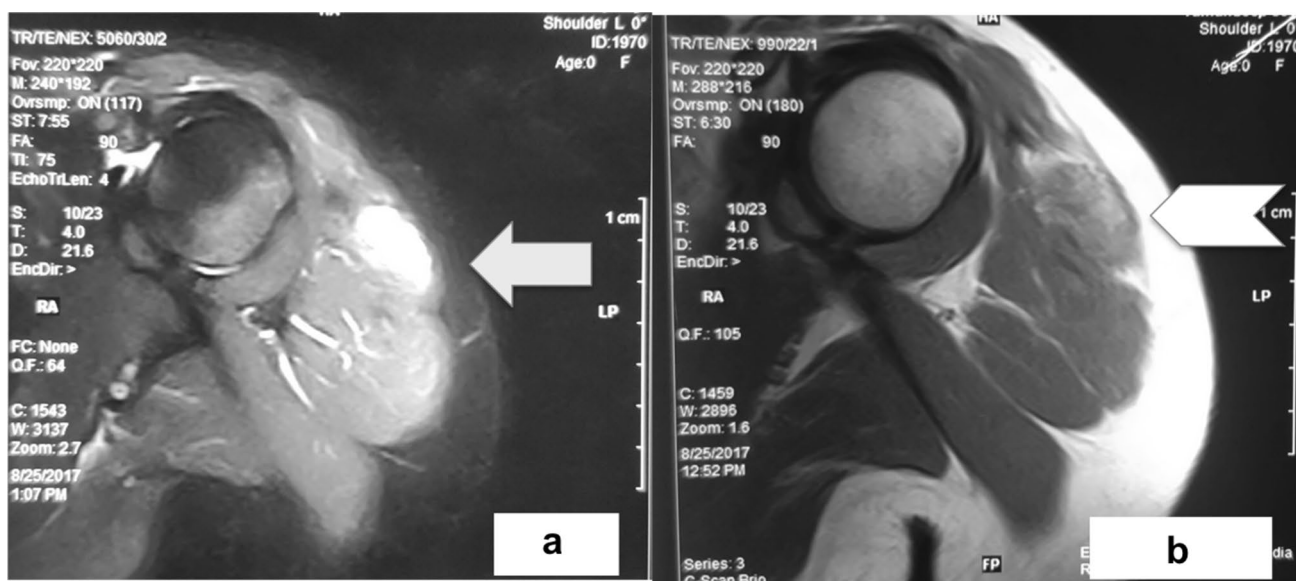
a MRI film of left shoulder showing a well-circumscribed T2 hyperintense lesion in the region of deltoid muscle (white arrow). b Same lesion which was hypo-iso intense on T1-weighted image (white chevron)
